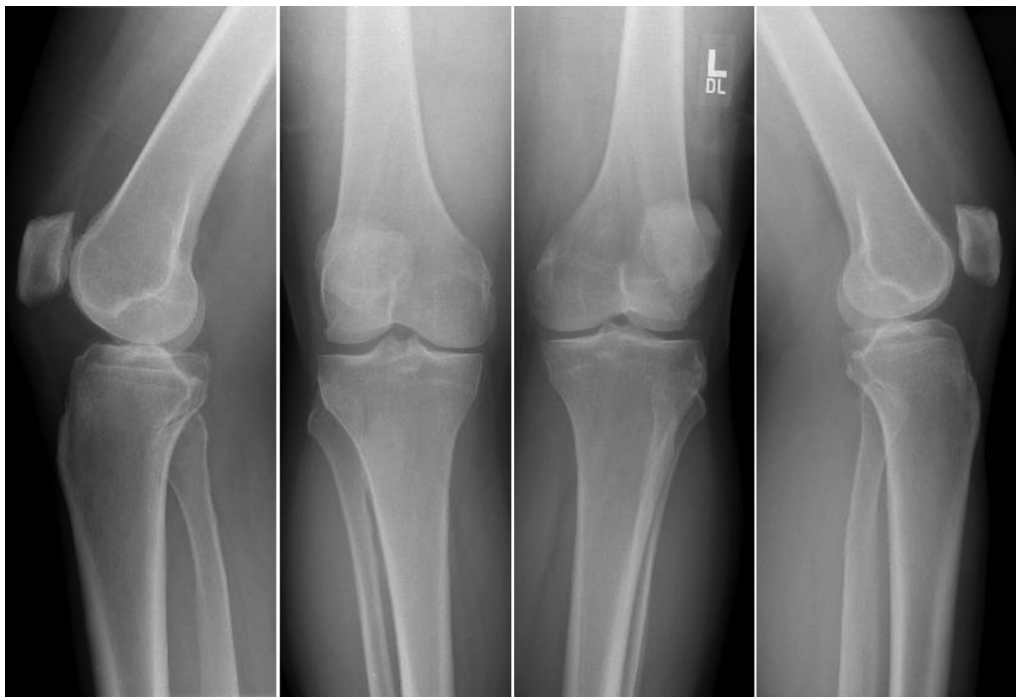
Sixty-six-year-old male with several years of bilateral knee pain. Knee radiographs revealed Grade 2 right knee OA and Grade 1 left knee OA.
